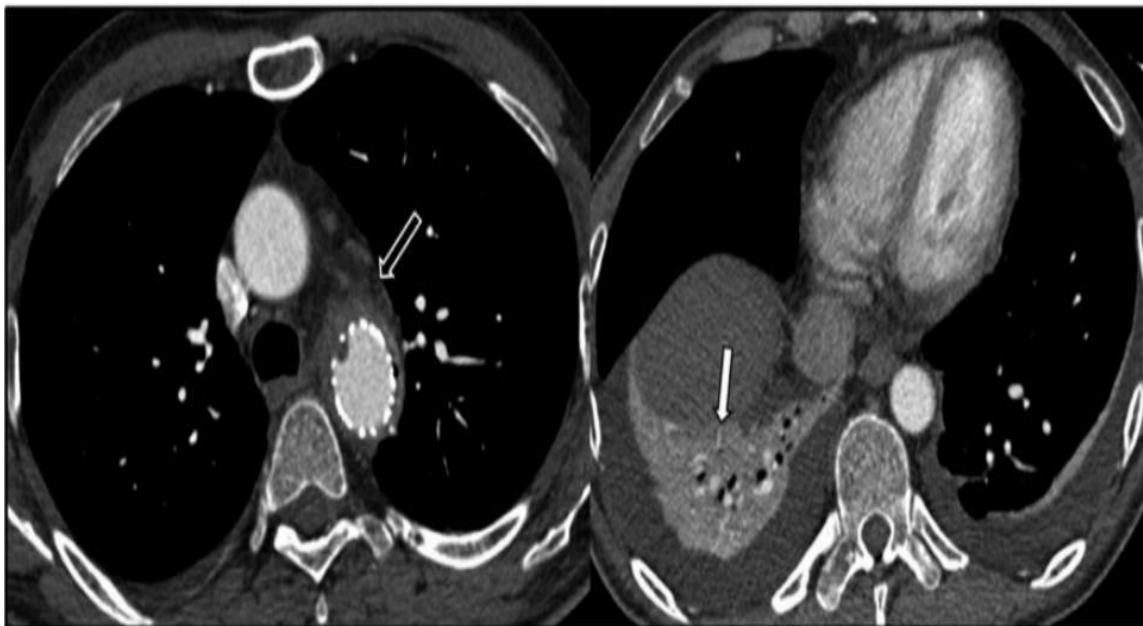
Axial CT angiogram sections below the level of the aortic arch, performed on June 11, 2017. Soft tissue thickening and stranding surrounding the descending thoracic aortic stent graft concerning graft infection (black arrow). There is no mediastinal fluid collection. There is right lower lobe consolidation and/or collapse (white arrow) and small bilateral pleural effusions. Abbreviation: CT, computed tomography.
